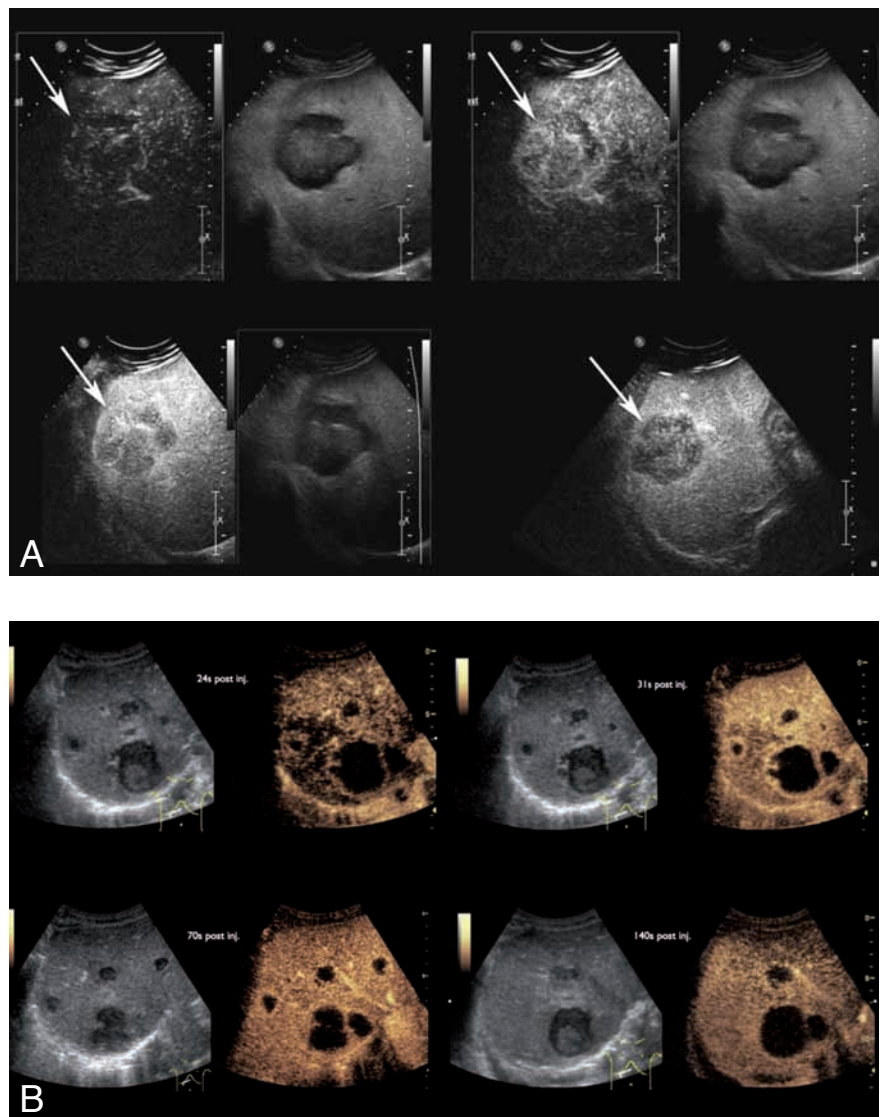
Contrast-enhanced ultrasound for characterization of liver lesions. A. Hypoechoic adenocarcinoma metastasis shows rapid enhancement after contrast agent administration with wash-out (arrows) in the liver-specific phase. B. Necrotic metastases from small cell lung cancer appear very hypoechoic. After contrast agent administration there is only minimal rim enhancement and no enhancement of the necrotic center.
